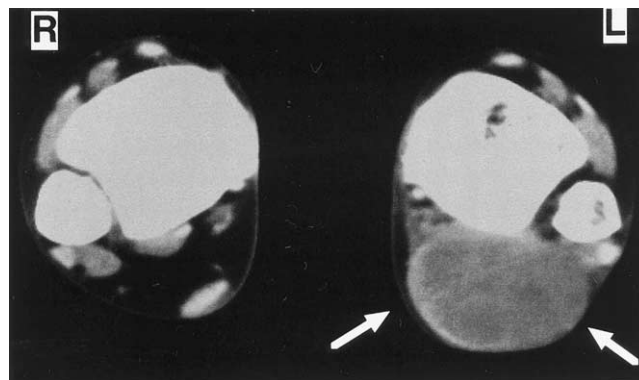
Enhanced computed tomography scan of the right and left Achilles tendons (transaxial scan). A tumor (46×32 mm) with marginal enhancement on the left Achilles tendon was revealed.
